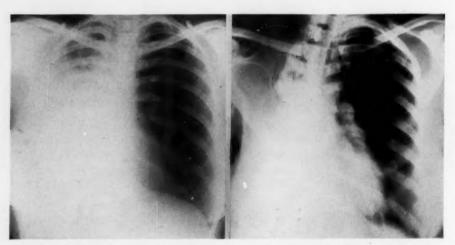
Case 2: Postero-anterior roentgenogram prior to thoracoplasty. The base is atelectatic. Questionable areas of cavitation at the level of the fifth and sixth ribs posteriorly.
